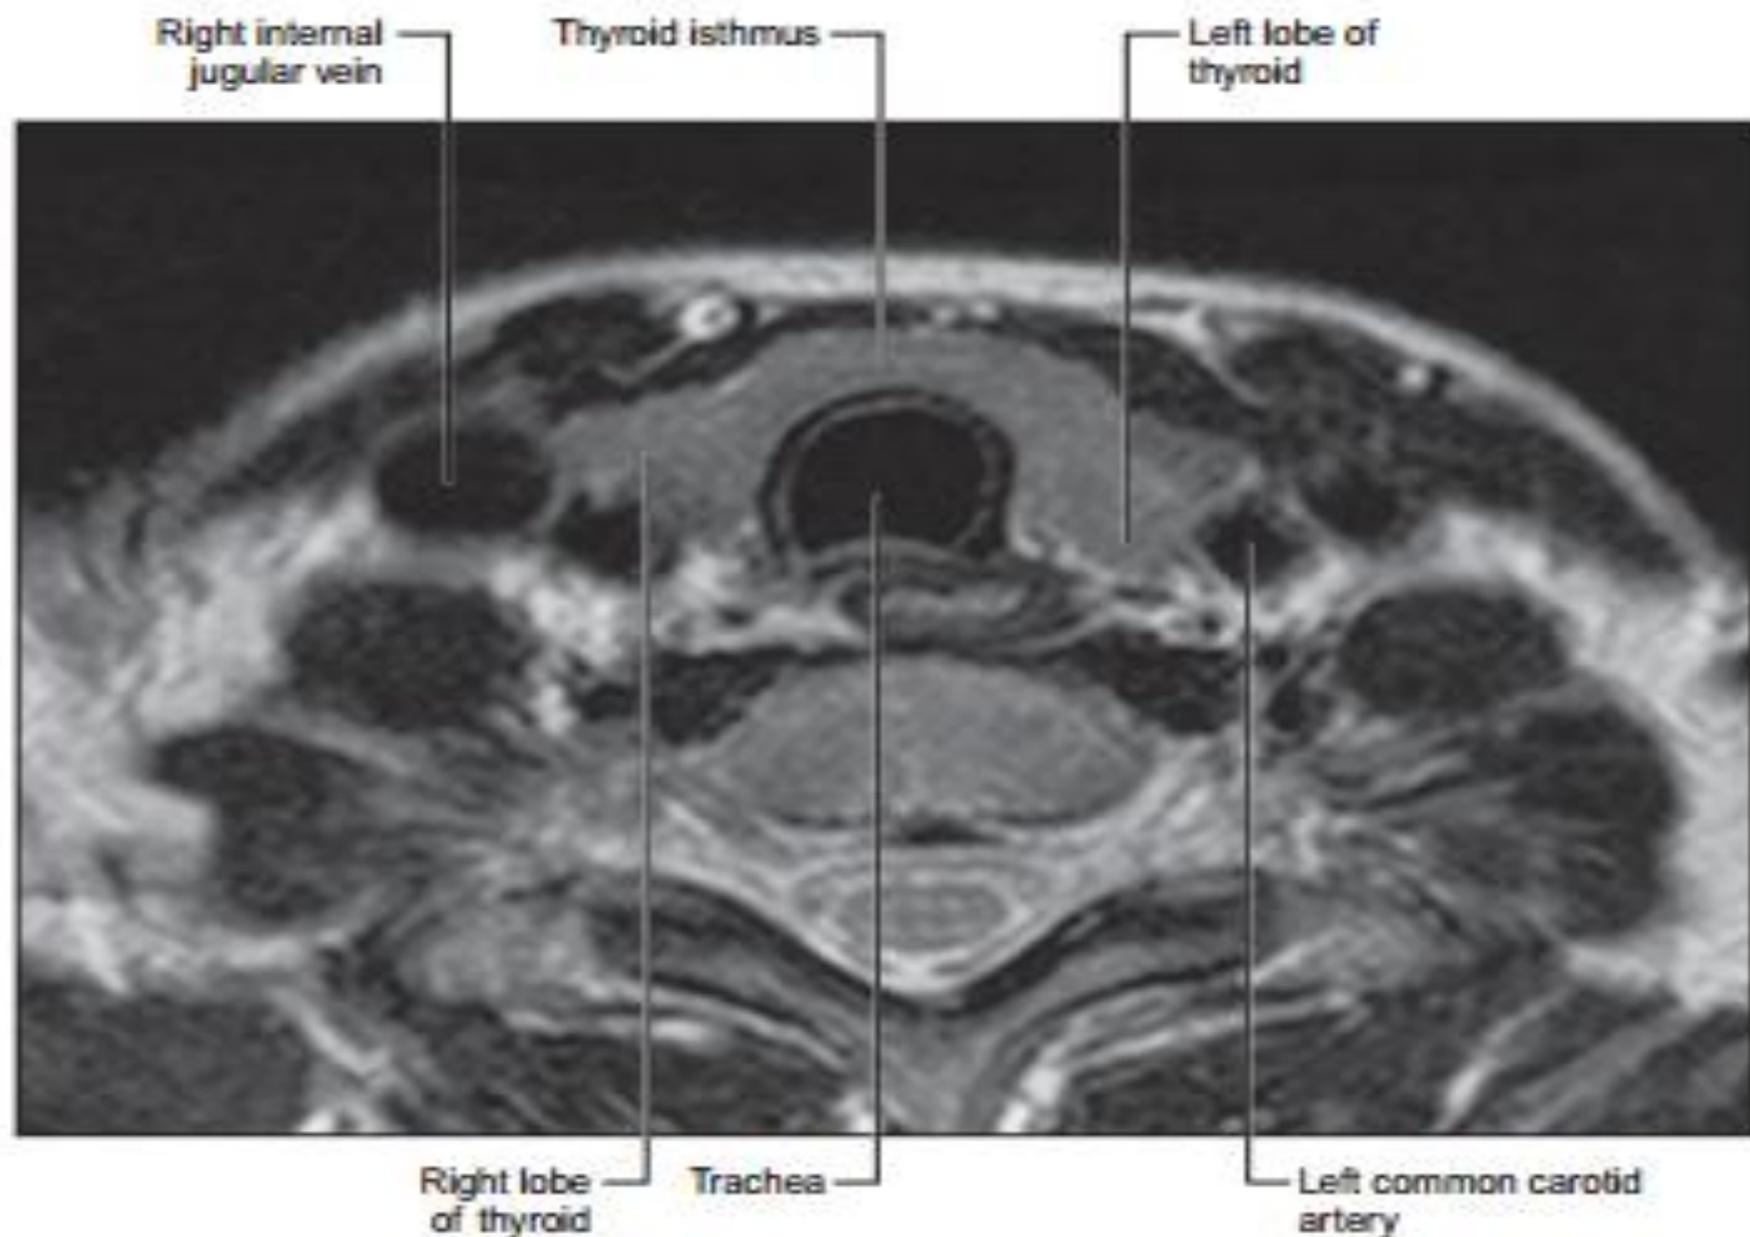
T₂-weighted MRI at the level of the thyroid isthmus: compare with Fig. 28.20.
